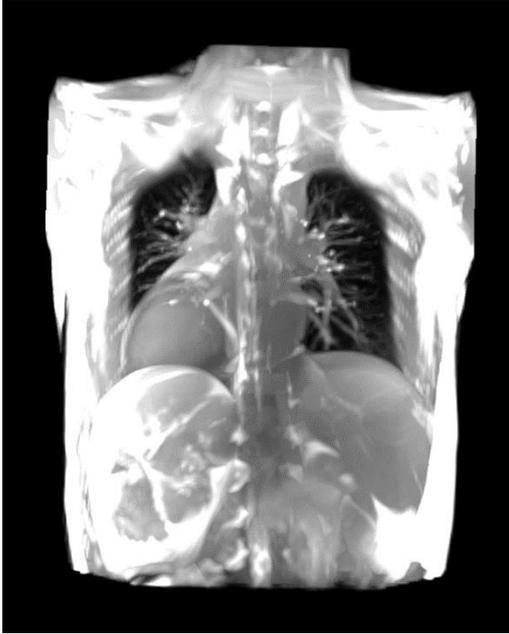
Maximum intensity projection of a 3D MRI scan of the lungs (Picture: A. Giger).
